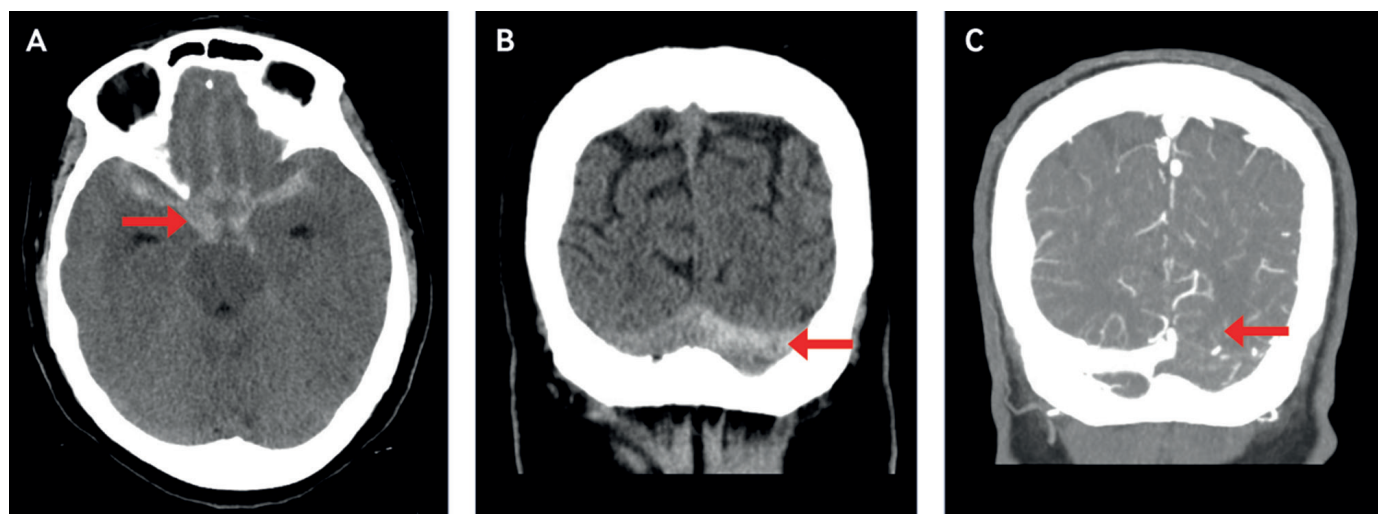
CT findings of subarachnoid haemorrhage (A) and cerebral venous sinus thrombosis (B/C). A: Acute subarachnoid haemorrhage most prominent in the prefrontal, suprasellar, bilateral cisterns of the lateral cerebral fossa. Axial images using 5 mm slices. B: Non-contrast CT head showing increased density along the left transverse sinus suggestive of acute venous sinus thrombosis. Coronal images using 5 mm slices. C: CT venogram of the head showing non-opacification of the left transverse sinus. Coronal images using 0.63 mm slices
